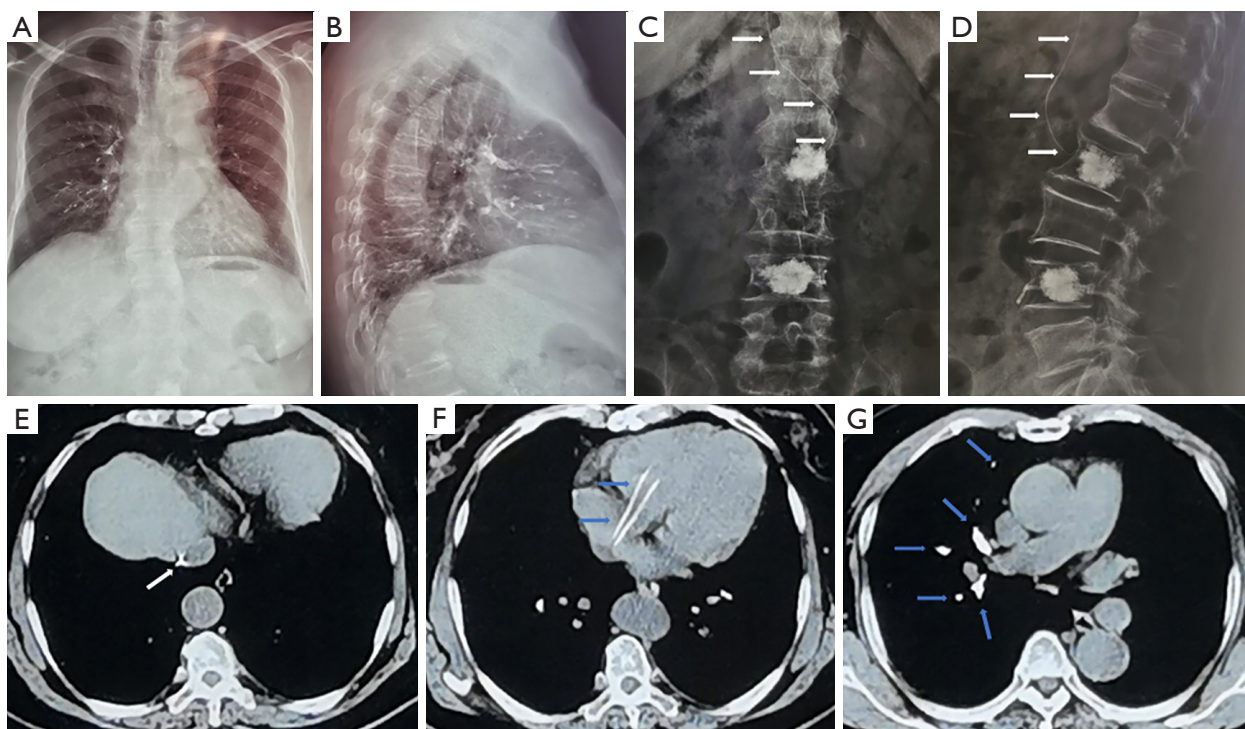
X-ray and CT findings of the patient. (A) Anteroposterior chest X-ray image. (B) Lateral chest X-ray image. (C) Anteroposterior lumbar spine X-ray image. (D) Lateral lumbar spine X-ray image. (E-G) Chest CT images. The white arrows indicate residual bone cement within the inferior vena cava. The blue arrows indicate residual bone cement within the heart and lung. CT, computed tomography.
